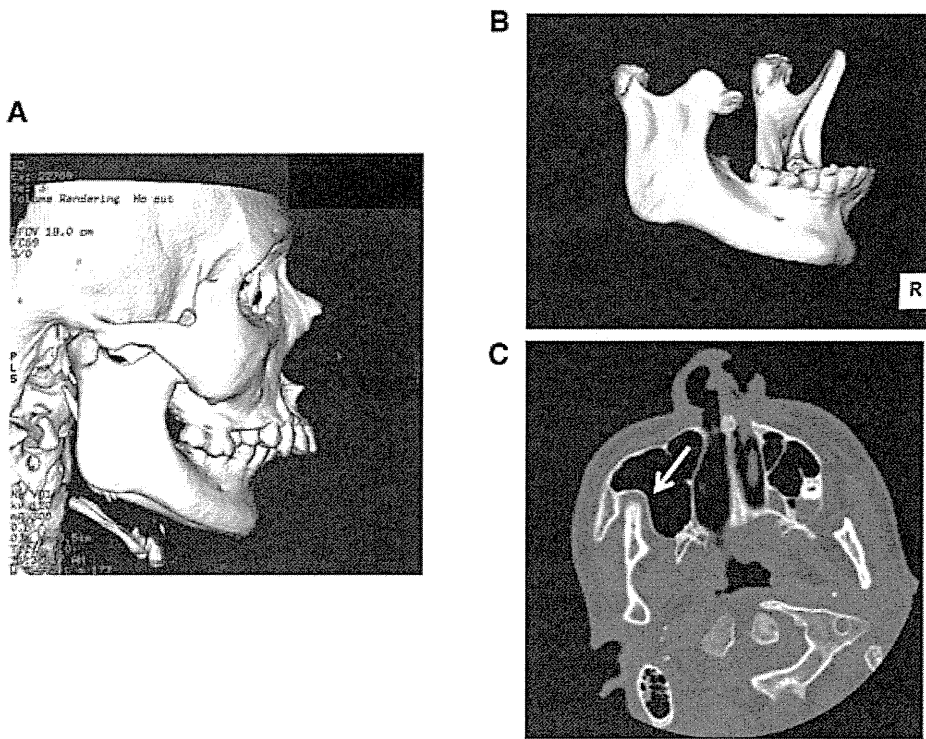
CT made at age 16 years and 3 months. (A) 3-D lateral facial view. (B) Extracted mandible. (C) 2-D view showing HO at the front edge of the right coronoid process. Deformation of bilateral condylar heads, widening of the right coronoid process, and elongation of left coronoid process were observed. HO was found at the anterior edge of the right coronoid process, but it was not fused with upper bones.
